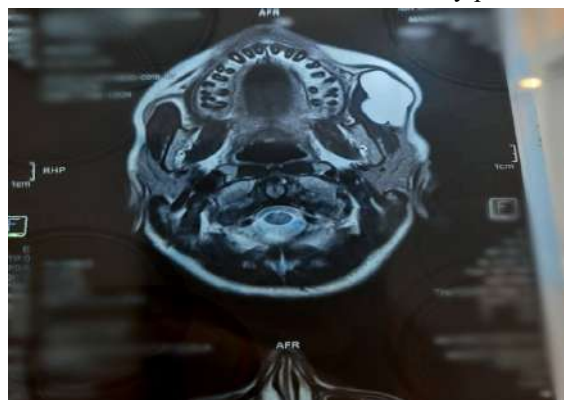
Axial T2-weighted MRI image showing a well-defined, hyperintense cystic lesion (arrow) measuring 4.2 x 2.8 cm, located superficial to the left masseter muscle and anterior to the main parotid gland.
